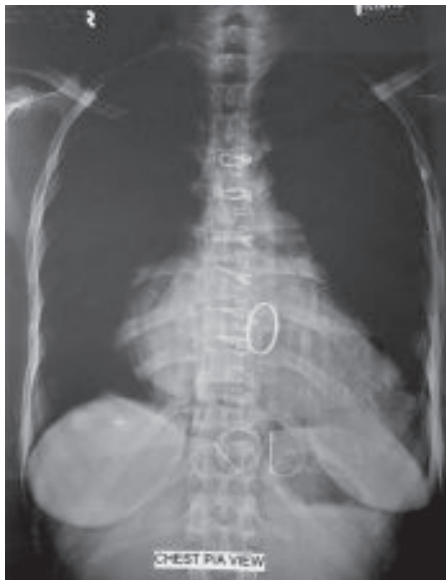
Post operative X-ray chest P/A view showing LA size has reduced.
